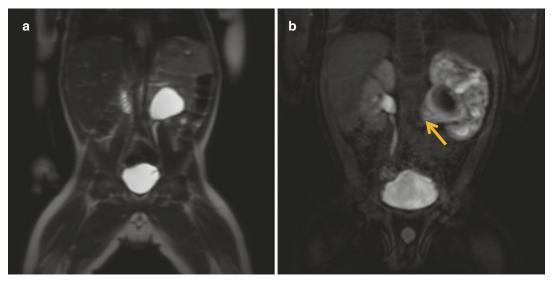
MR urography (MRU) of ectopic ureter. Ectopic ureteral insertion on MRU in a 2-year-old with urinary tract infections. (a) Coronal and (b) sagittal T2-weighted images demonstrate a right-sided duplicated
